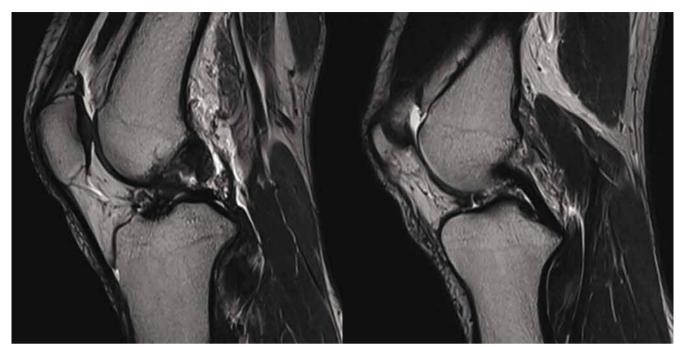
MRI 8 days after the injury. Sagittal fat-saturated T2-weighted image using PET/MR Biograph – mMR 3T. The anterior cruciate ligament described by a radiology specialist as "in continuity with increased signal strength". No secondary signs of ACL tear such as tibiofemoral translation or vertical PCL
